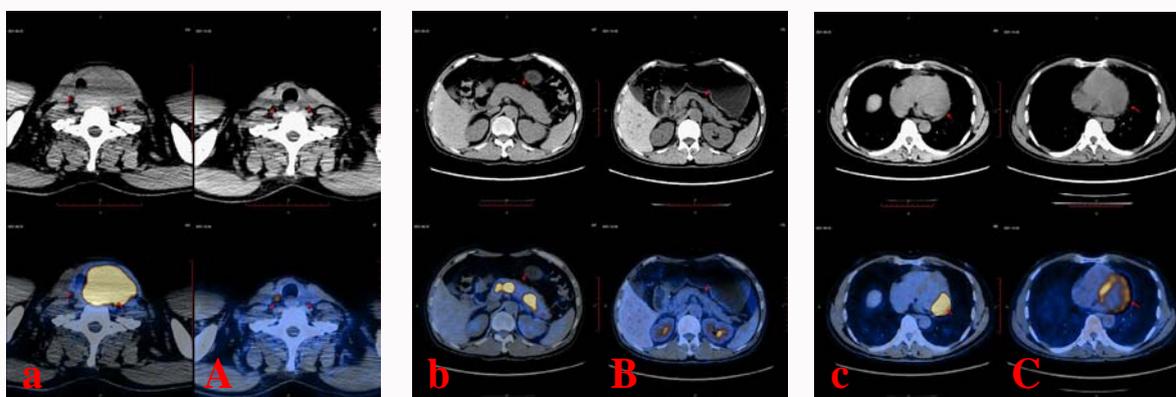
(a-c): The PET-CT revealed abnormal hypercritical metabolism of residual thyroid, pancreas and heart ventricle respectively at diagnosis on August 23, 2021; (A-C): The PET-CT revealed respectively the lesion of pancreas, residual thyroid and heart ventricle had greatly reduced or even disappeared after 4 courses of R -CHOP regimen therapy.
